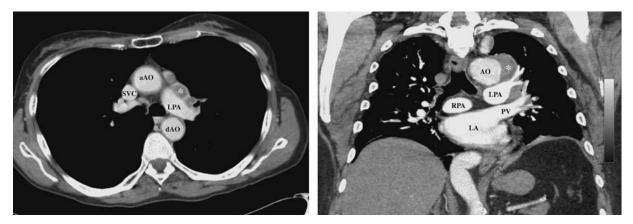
Axial and coronal CT chest showing lymph node in station 5 (*) in a patient who refused CT-guided needle biopsy or surgery and with negative cytology on other lymph node stations. Trans-PA EBUS confirmed adenocarcinoma (N2). aAO indicates ascending aorta; CT, computed tomography; dAO, descending aorta; EBUS, endobronchial ultrasound; LA, left atrium; LPA, left pulmonary artery; PA, pulmonary artery; PV, pulmonary vein; RPA, right pulmonary artery; SVC, superior vena cava.
